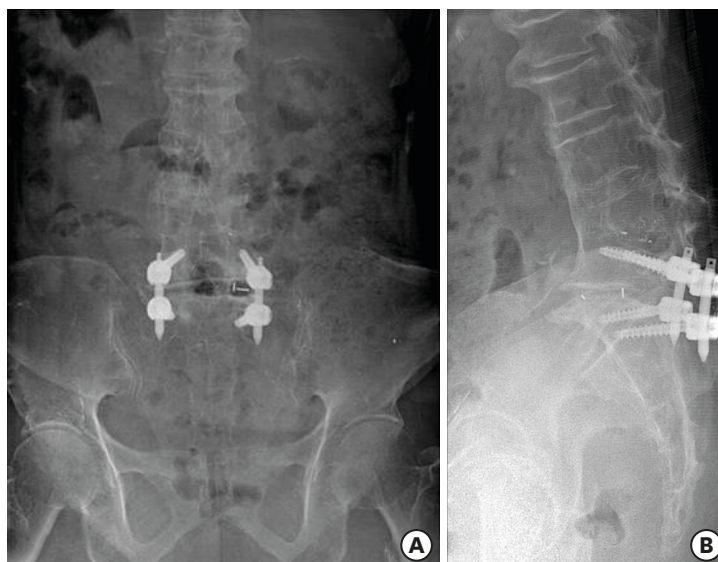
Postoperative simple radiographs (A & B) taken 6 months after the posterior lumbar interbody fusion at the L5-S1 level.
